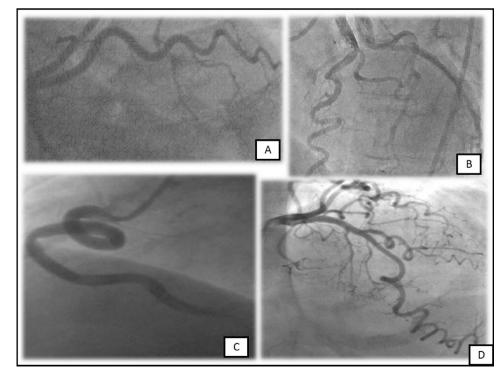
Consist of 4 parts describing the degree of angulation of coronary tortuosity (CT). A = Mild CT in Ramus intermedius, B = Moderate CT in LAD, C = Extreme CT with loop in RCA, D = Sever CT in LAD. LAD; left anterior descending artery, LCX; left circumflex artery, RCA; right coronary artery.
